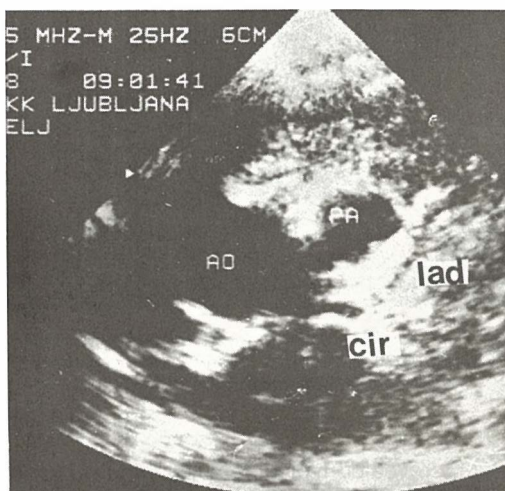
Short axis parasternal view of the left anterior descending coronary artery (lad) and circumflex branch of the left coronary artery (cir). AO = aorta, PA = pulmonary artery.
